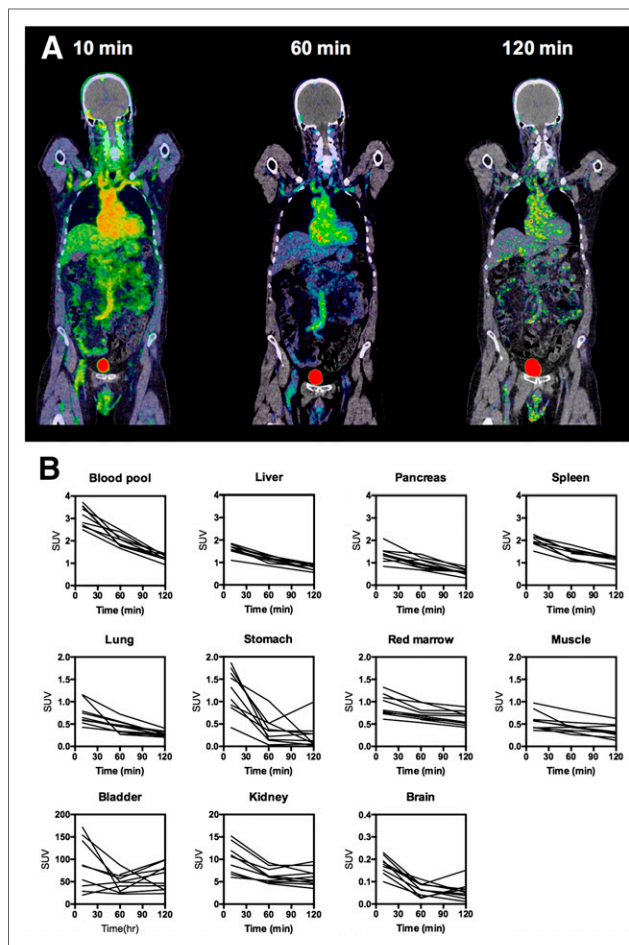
Whole-body distribution and SUV in major organs after injection of ^{68}Ga -NOTA-AE105. (A) Maximum-intensity-projection PET images at 10 min, 1 h, and 2 h after injection of ^{68}Ga -NOTA-AE105 (patient 2). Highest accumulation of activity was in kidneys and bladder. (B) Decay-corrected SUVs in blood and major organs plotted individually for $n = 10$ patients. For each patient, regions of interest were drawn on selected organ of interest at all 3 consecutive PET scans.
